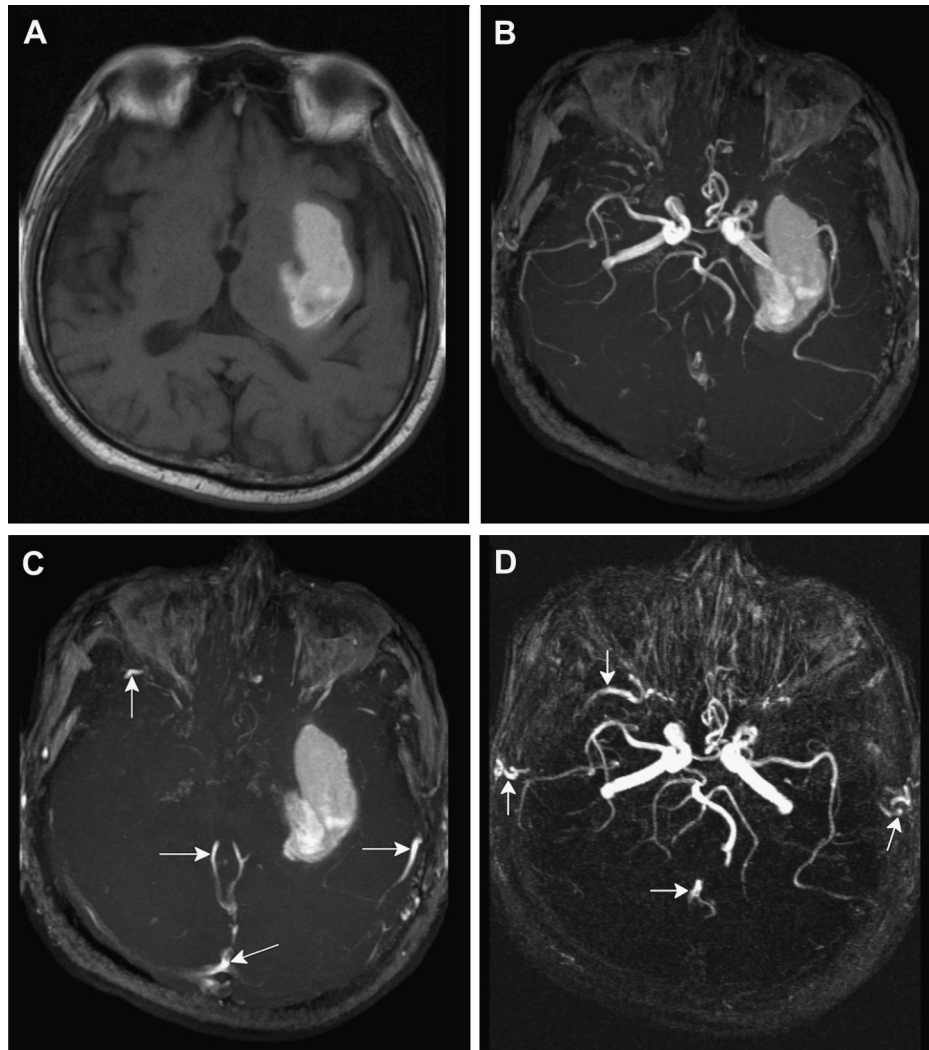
Intracerebral hemorrhage in a 65-year-old male who presented with acute-onset right-sided weakness. (A) Axial T1-weighted image through the basal ganglia showing a short T1 hematoma in the left cerebrum. (B) Axial conventional three-dimensional (3D) time-of-flight magnetic resonance (TOF MR) angiogram of the circle of Willis showing a large short T1 hematoma obscuring the M1 segment of the left middle cerebral artery. For the selectively displayed arterial anatomy, both observers assigned the image quality scores of 2. (C) Axial second set 3D TOF MR angiogram acquired with both superior and inferior spatial saturation slabs showing most blood vessels as dark. The short T1 hematoma still appears bright. Multiple high signals (arrows) from the inflowing venous system were inadvertently not removed in the case. (D) Axial subtraction 3D TOF MR angiogram clearly showing the M1 segment of the left middle cerebral artery after removal of the hematoma. There is no aneurysm in the circle of Willis. The inadvertent high-signal venous contaminations in the second set of MR angiograms do not affect the subtraction MR angiogram with our technique. Even so, there are still some venous structures (arrows) from incomplete suppression on the image. For the selectively displayed arterial anatomy, both observers assigned the image quality scores of 0.
